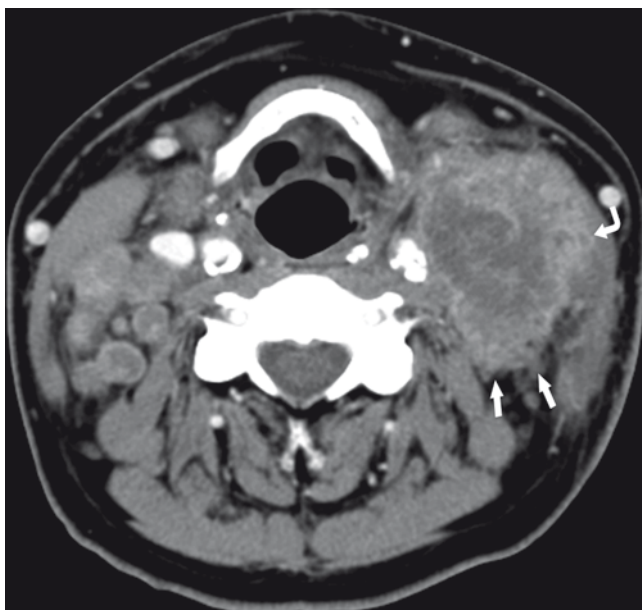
Extracapsular extension (ECE). CT image shows extensive bilateral nodal disease, but the large left-sided node has very irregular margins, especially posteriorly (*straight arrows*), and very blurred margins between the node and the medial surface of the sternocleidomastoid muscle (*curved arrow*)
